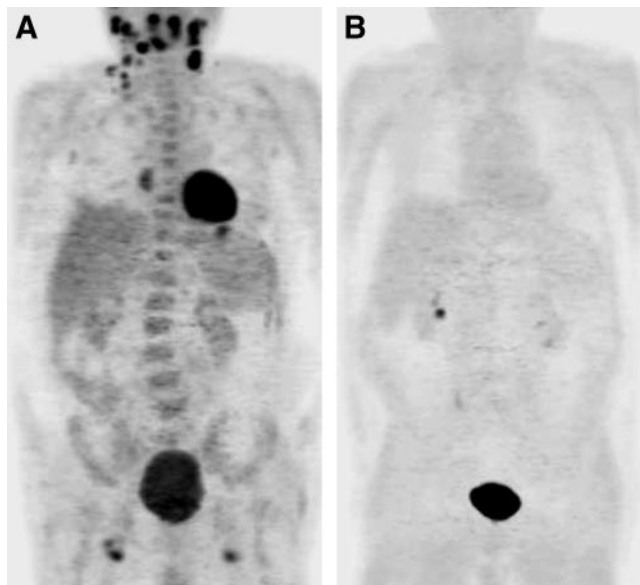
^{18}F -FDG PET (A) and ^{18}F -FET PET (B) of 81-y-old man (patient 2) with high-grade lymphoma (non-Hodgkin's lymphoma). ^{18}F -FDG shows high uptake in multiple lymph nodes, whereas ^{18}F -FET uptake is negative in all lymph nodes.
